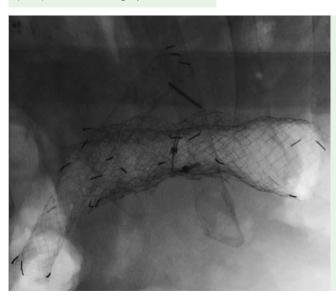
Radiographic images following the extraction of the migrated part of the self-expanding metal stent (SEMS) showing a second duodenal SEMS positioned in the remnant of the original SEMS. The patent biliary SEMS, which remains in place, is also shown.
